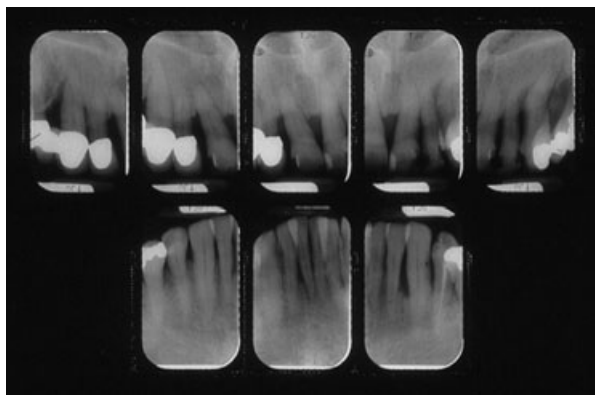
Anterior preoperative periapical radiographs of a patient who presented with mobile teeth and inflamed periodontal tissues. This patient was classified as PDI Class IV having moderate/severe periodontitis. The maxillary teeth presented with a hopeless prognosis.
